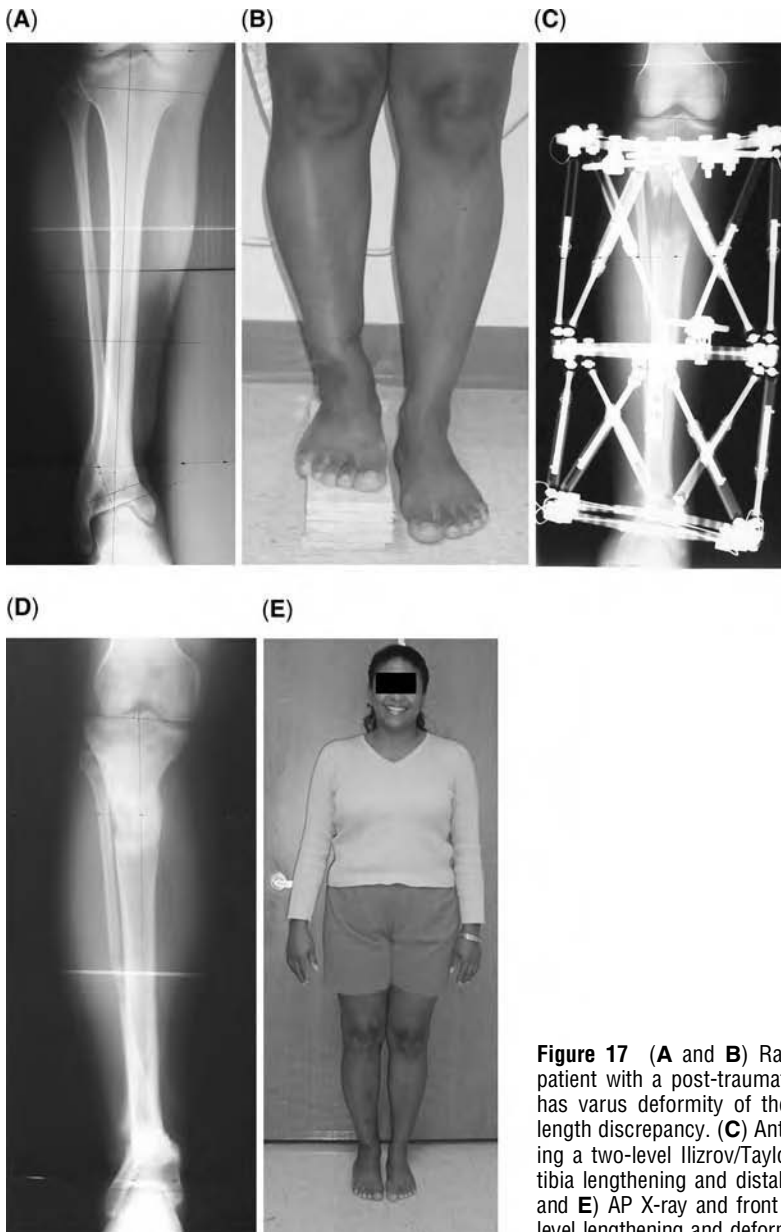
(A and B) Radiograph and front view of a patient with a post-traumatic growth arrest. This patient has varus deformity of the distal tibia and 6 cm of leg length discrepancy. (C) Anteroposterior (AP) X-ray showing a two-level Ilizarov/Taylor spatial frame with proximal tibia lengthening and distal tibia deformity correction. (D and E) AP X-ray and front view showing successful two-level lengthening and deformity correction.
